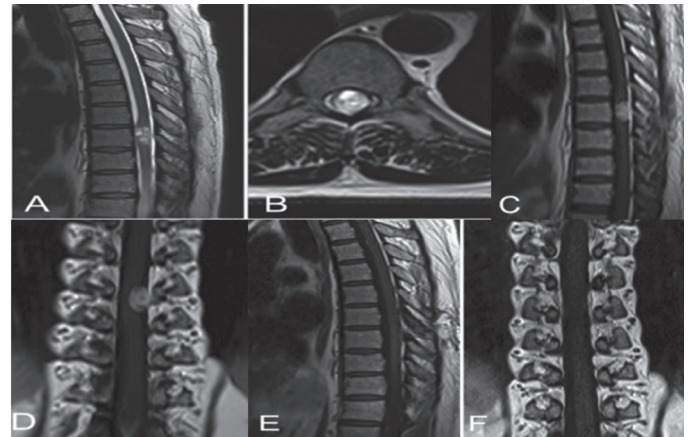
A 50-year-old male patient who presented with low back pain and numbness in both lower regions. Pre-op T2 sagittal (A) and axial (B) MR images, sagittal (C) and axial (D) contrast MR images. T1-weighted sagittal (E) and axial (F) images with contrast 3rd month postop, postop axial CT image
